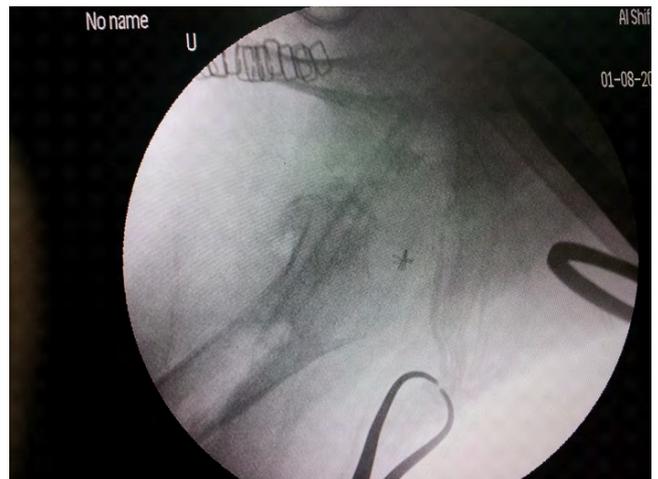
Post op X-Ray on hip spica cast.
